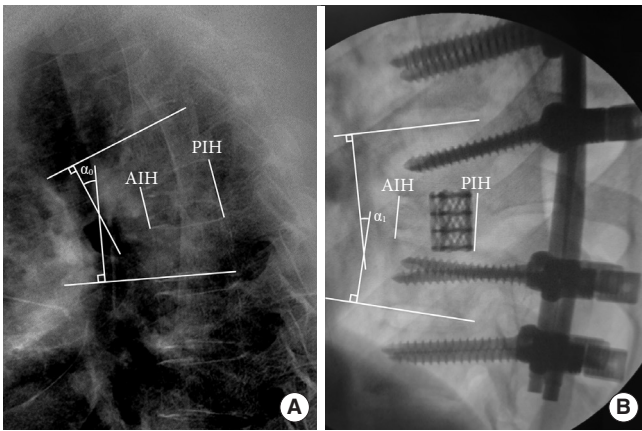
Radiological measurement of mean intervertebral height (MIH) and Cobb angle (α_0) in preoperative (A) and postoperative images (B). MIH was measured as the average of anterior intervertebral height (AIH) and posterior intervertebral height (PIH) on sagittal plain radiograph. Whereas AIH was the distance between the most anterior point of the inferior edge of the upper vertebra and the most anterior point of the superior edge of the lower vertebra, while PIH was the distance between the most posterior point of the inferior edge of the upper vertebra and the superior edge of the lower vertebra. Kyphotic Cobb angle (α_1) was measured as the angle between the superior endplate of the vertebral body above the affected level and the inferior endplate of the vertebral body below the affected level.
